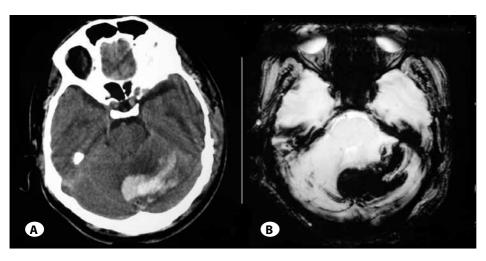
Axial CT scan (A) and MRI gradient echo scan (B) obtained 36 hours after surgery shows the left cerebellar haemorrhage with typical streaky, curvilinear bleeding pattern with blood in the cerebellar sulci.
